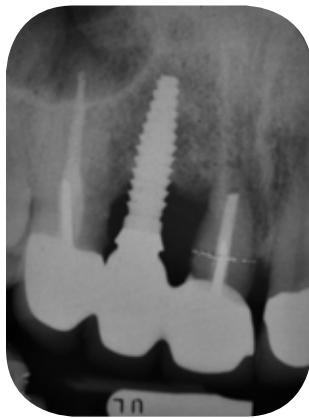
Intraoral X-ray. The implant in position 1.2 shows a severe peri-implantitis, with appreciable bone loss. Teeth 1.1 is lost. / Radiografia intraorale. Implanti ne pozicionin 1.2 tregon peri-implantit te rende me humbje te konsiderueshme te kockes. Dhembja 1.1 eshte i humbur.
